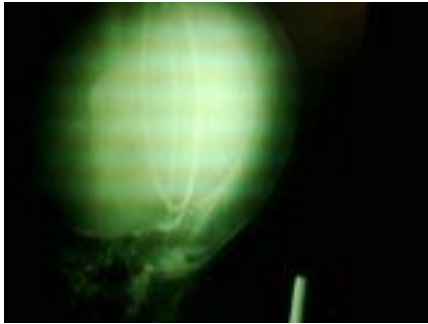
Computed tomography showing intraventricular shunt catheter
